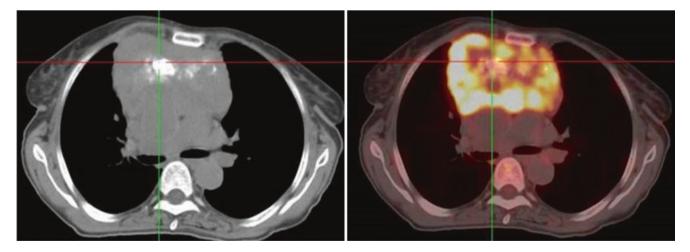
A 64-year-old woman with thymic squamous cell carcinoma, the maximum SUV value was 9.9
